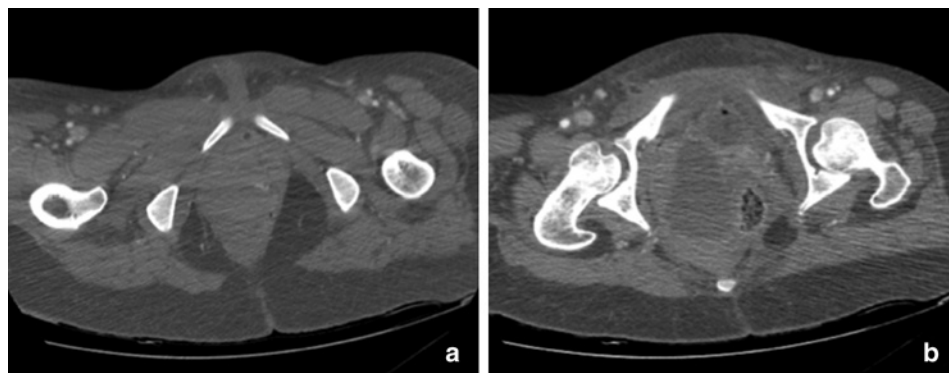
CT scan of a pelvic haematoma. Contrast-enhanced CT shows (a) the bleeding site and (b) pelvic hematoma.
